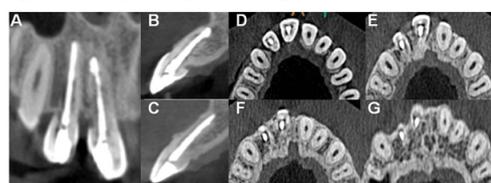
CBCT images showing replacement resorption of maxillary central & lateral incisor: A - Coronal images. B, C - Sagittal images. D, E, F, G - coronal, middle and apical axial images.
